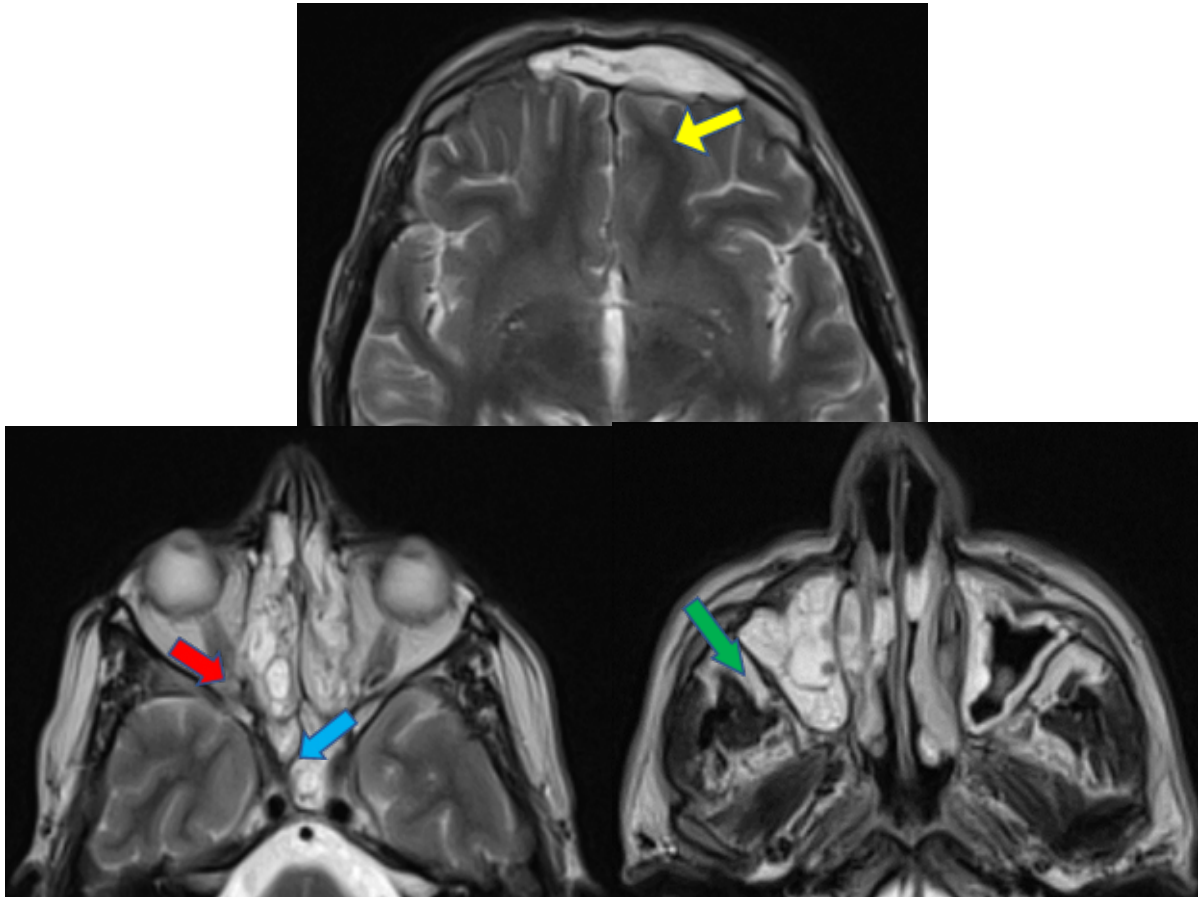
Axial T2-weighted MRI images of an abnormal patient. (LM score=19) shows the hyperintense thickened sinus mucosa in the frontal (yellow arrow), ethmoid (red arrow), sphenoid (blue arrow), and maxillary sinuses (green arrow).
